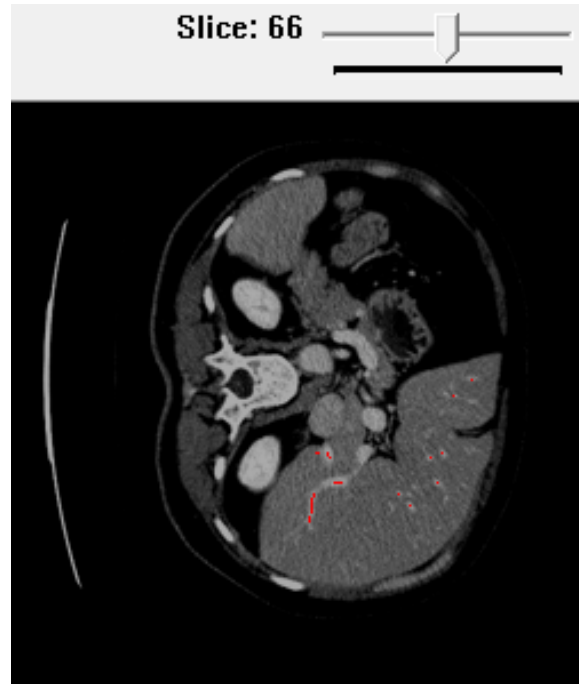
The approximate root point selector interface where the skeleton image (red) is shown on an axial slice of a CT image
